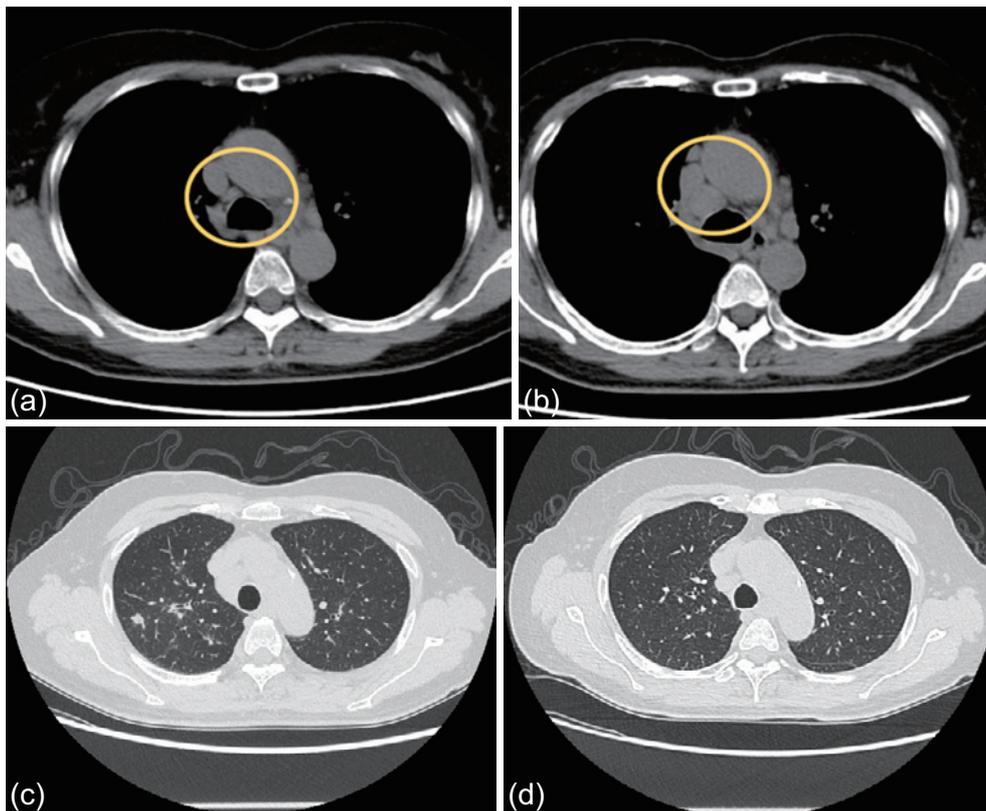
(a, b) Chest CT revealed enlargement of a paratracheal lymph node (b: circle) after initiation of adalimumab (a: circle). (c) Chest high-resolution CT at 26 months disclosed centrilobular nodules in both lungs. (d) Chest high-resolution CT at 37 months showed mitigation of the signs shown in (c).
